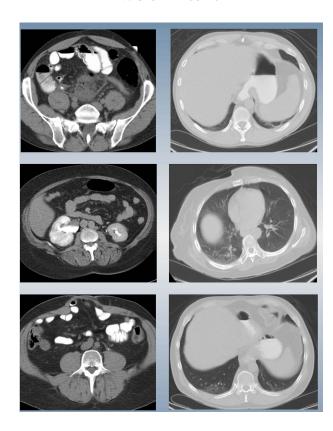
Axial view of CT scan of an individual with basilar atelectasis with an underlying abdominal-pelvic pathology on the ipsilateral side.
